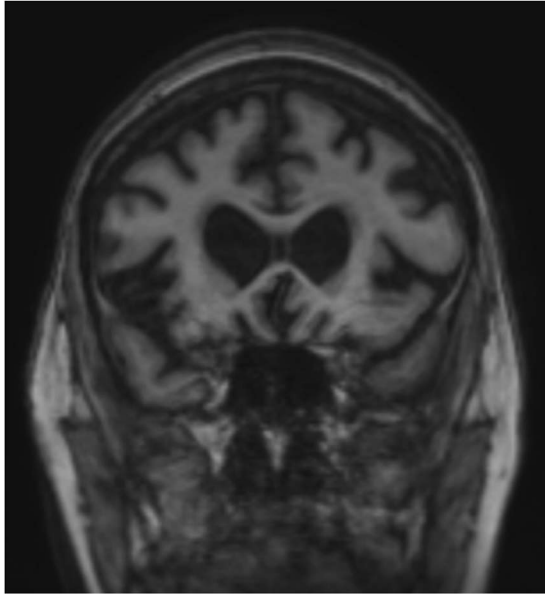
Coronal MRI of Case 5 showing moderate dorsolateral, ventrolateral, and ventromedial prefrontal and insular cortical atrophy, suggestive of the pattern of atrophy seen in frontotemporal dementia.
